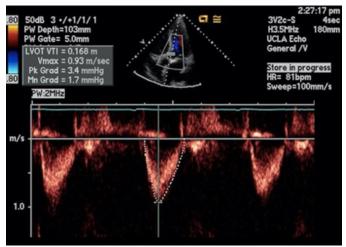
Repeat TTE at Sixteen Months of Anticoagulation: Apical five-chamber view reveals that the aortic valve pressure gradients and calculated valvular area are back to his baseline.
